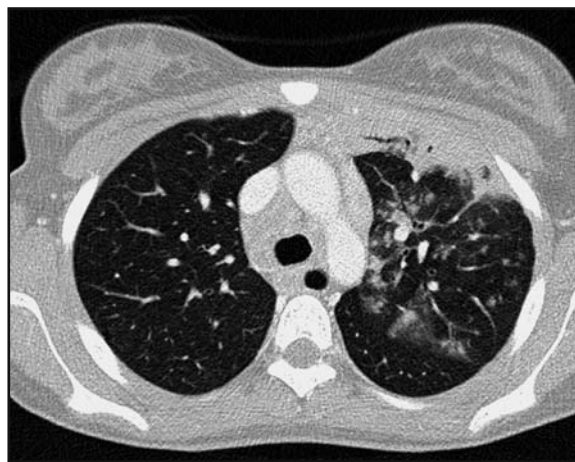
Tuberculosis in a 14-year-old girl. a Chest CT scan (collimation 12×0.75 mm) shows areas of consolidation in left upper lobe associated with centrilobular nodules in the lung periphery (arrows). Mediastinal lymphadenopathy in the right paratracheal and aortopulmonary window stations is also present. b Coronal reformatted image shows consolidation and associated cavitation
